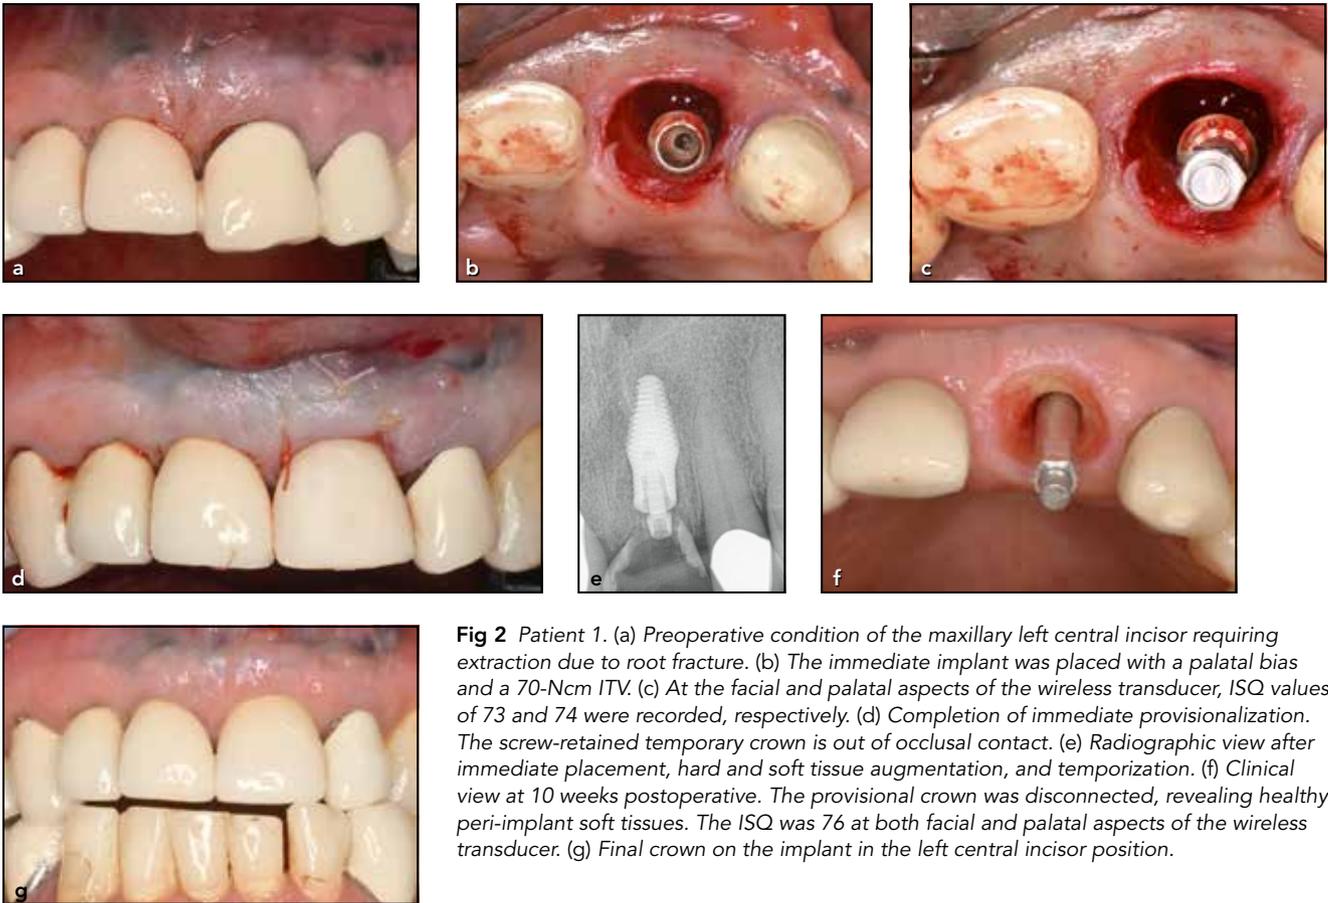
Patient 1. (a) Preoperative condition of the maxillary left central incisor requiring extraction due to root fracture. (b) The immediate implant was placed with a palatal bias and a 70-Ncm ITV. (c) At the facial and palatal aspects of the wireless transducer, ISQ values of 73 and 74 were recorded, respectively. (d) Completion of immediate provisionalization. The screw-retained temporary crown is out of occlusal contact. (e) Radiographic view after immediate placement, hard and soft tissue augmentation, and temporization. (f) Clinical view at 10 weeks postoperative. The provisional crown was disconnected, revealing healthy peri-implant soft tissues. The ISQ was 76 at both facial and palatal aspects of the wireless transducer. (g) Final crown on the implant in the left central incisor position.
